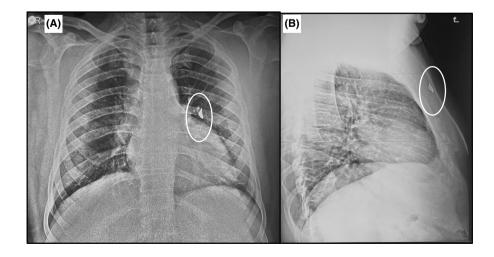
(A, B) Chest radiograph frontal and lateral view showing wedge shaped opacity (white circle) in left anterior chest wall.
